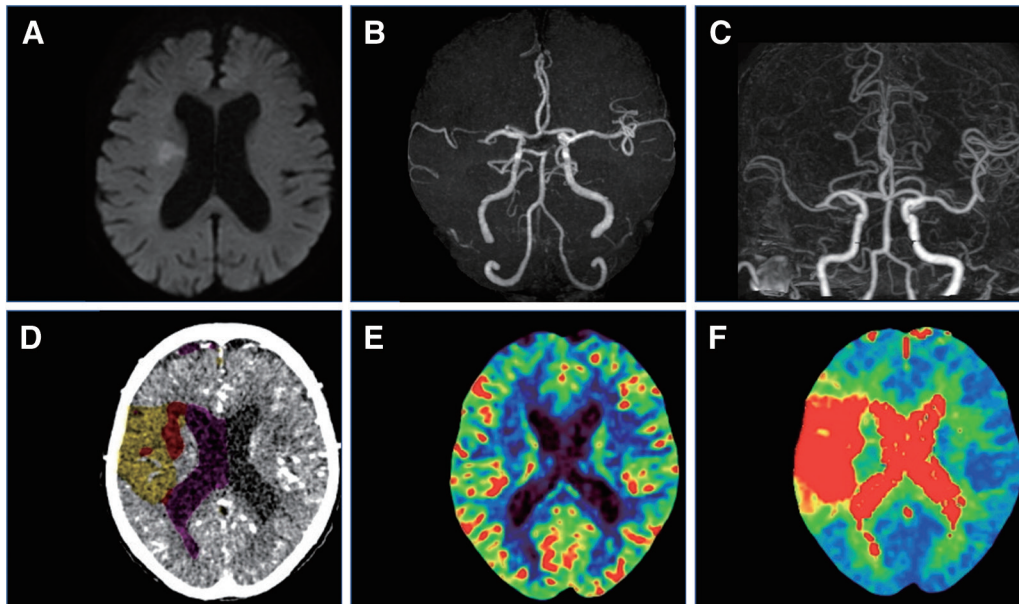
Analysis of head MRI/MRA and Bayesian CT perfusion. (A) Head DWI image showing a high-intensity area around the right lateral ventricle. (B) Head MRA image showing occlusion of the right middle cerebral artery M2. (C) CTA image of the head showing occlusion of the right middle cerebral artery M2. (D) Vitrea summary map showing the ischemic core volume as a red area and the ischemic penumbra volume as a yellow area. (E) CBV with decreased blood flow in 38% of the ischemic core region is shown in blue around the right ventricle. (F) TTP with the ischemic penumbra region in the right cerebral hemisphere is shown in red, indicating an area of delayed TTP contrast compared to the contralateral side at 5.3 s. CBV: cerebral blood volume; DWI: diffusion-weighted MRI; TTP: time to peak
